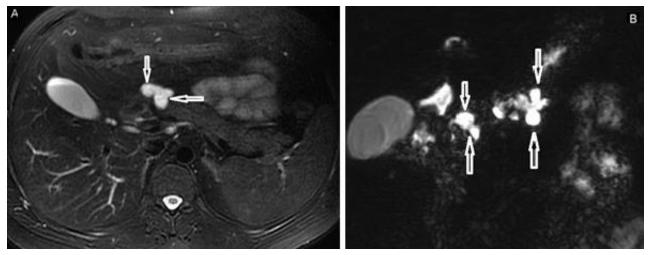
Axial fat-satured T2W upper abdomen MRI showed that cystic enlargements with minor duct IPMN were located at the head of pancreas (arrows) (a) MRCP image demonstrates multiple cystic enlargements in the body and tail of the pancreas (arrows) (b)
